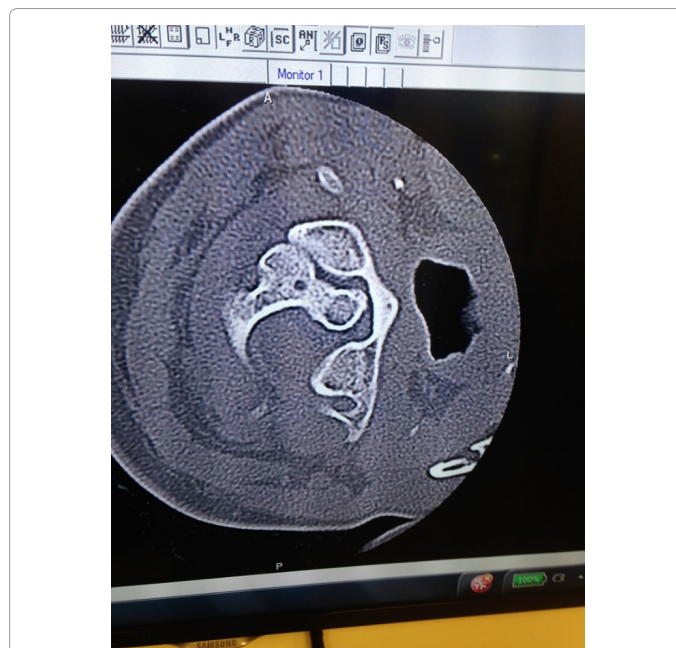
Axial CT scan through C1-C2 showing loss of facet overlap on full neck rotation, consistent with AAI.
